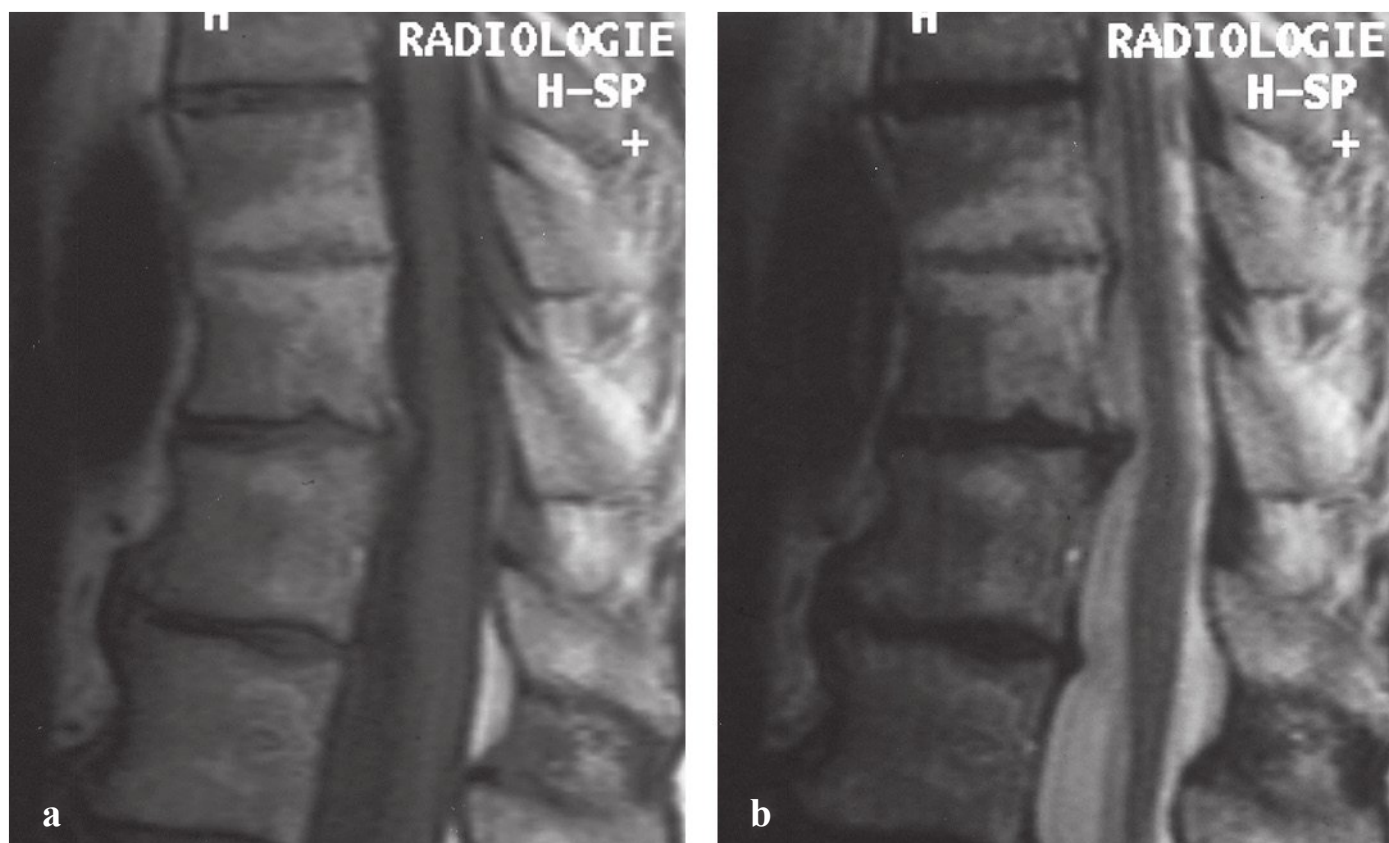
(a,b) Sagittal magnetic resonance imaging demonstrating type 3 Modic changes. (Reproduced from Uhlenbrock D. MR Imaging of the Spine and Spinal Cord. Stuttgart, Germany: Georg Thieme Verlag; 2004: Fig. 4.33, with permission.)
